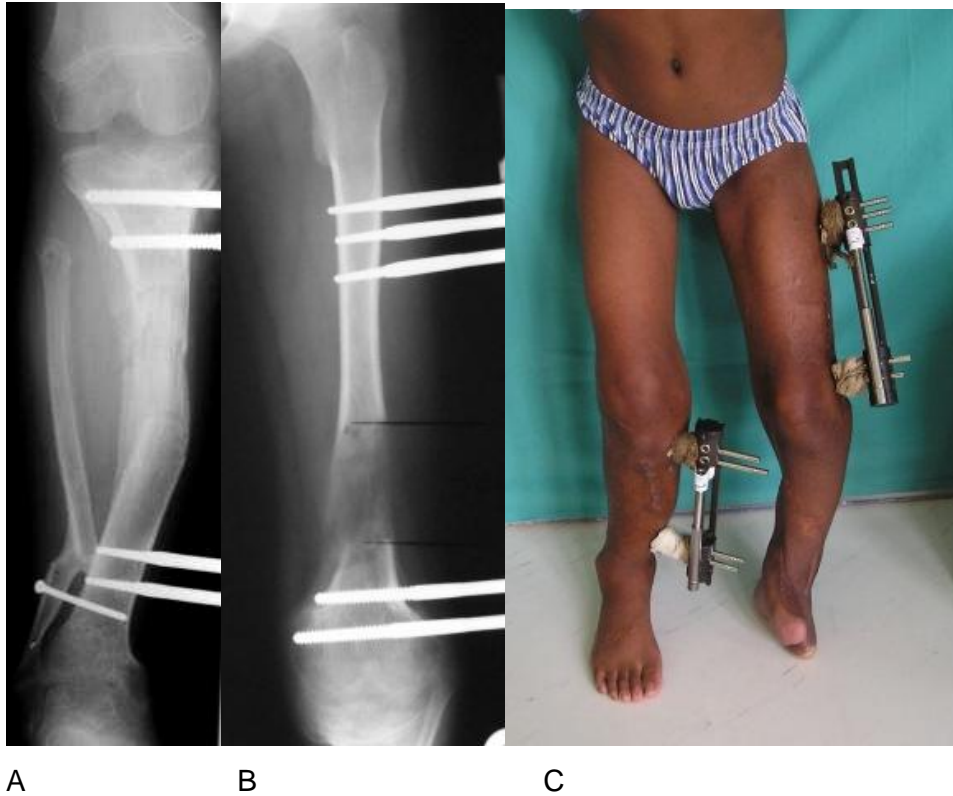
A-P radiograph of the right tibia and left femur of the same patient shown in figure 2B. Simultaneous angular correction and 6 cm lengthening of tibia were done. Note distal migration of proximal fibular head. The left femur was lengthened 5cm. Figure 10C. Clinical picture; left tibial varus and shortening still have to be addressed.
